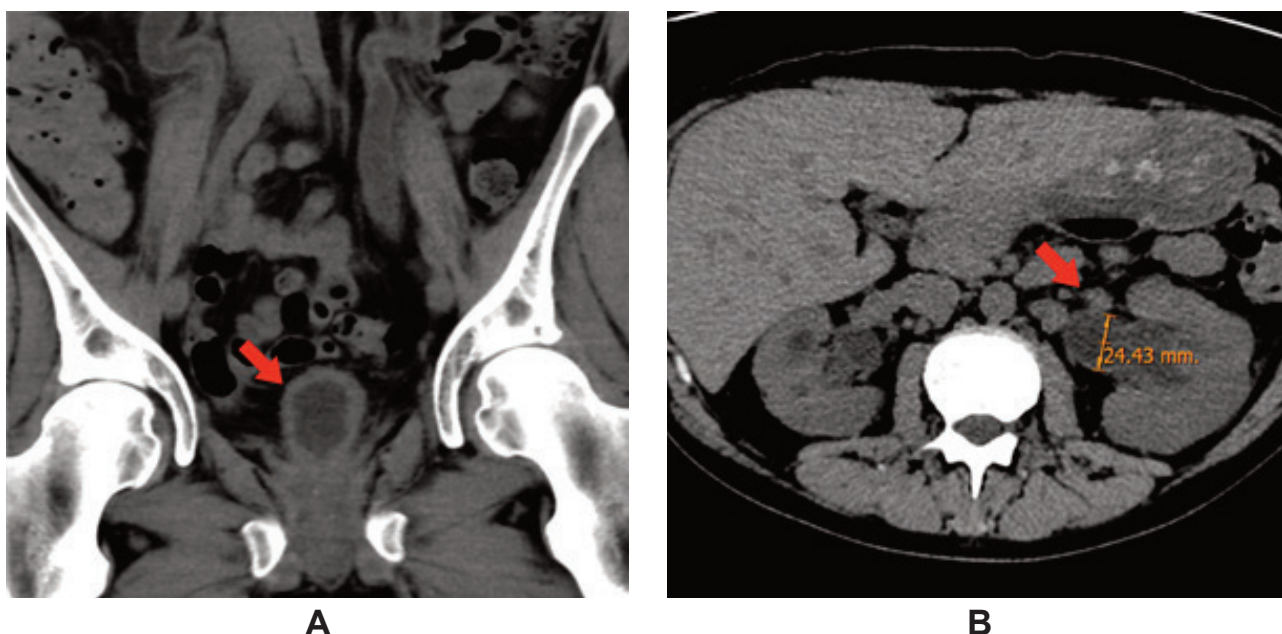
Abdominopelvic CT images. A. Coronal view showing a low-capacity bladder with diffuse mural thickening (red arrow), consistent with chronic cystopathy. B. Axial view showing a dilated ureter measuring 24.4 mm (red arrow), consistent with uronephrosis secondary to obstructive bladder dysfunction (Credits: courtesy of the authors).
